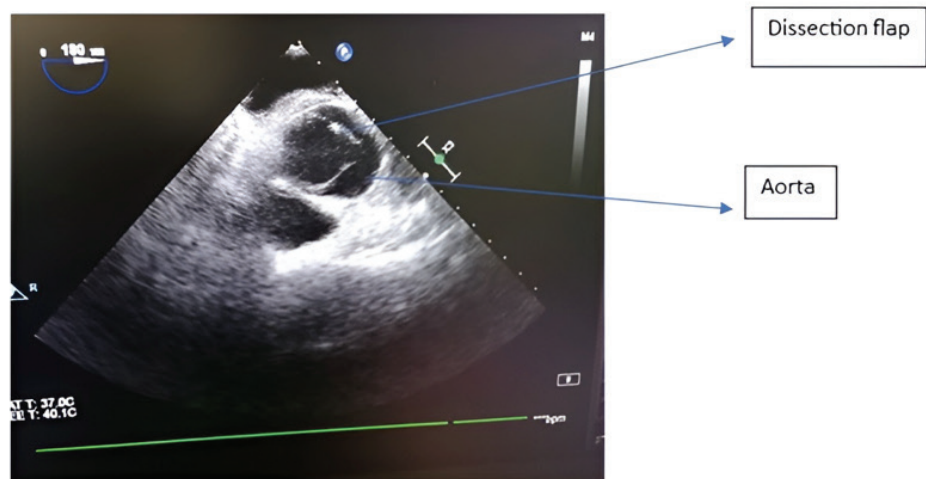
Transoesophageal echocardiography showing dissection flap.
